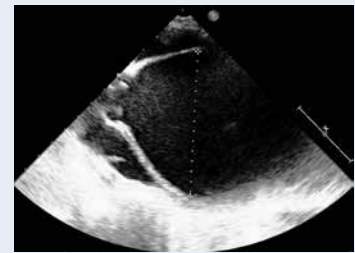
Echocardiography study showing an aneurysmal dilatation of the ascending aorta, immediately past the aortic valve
